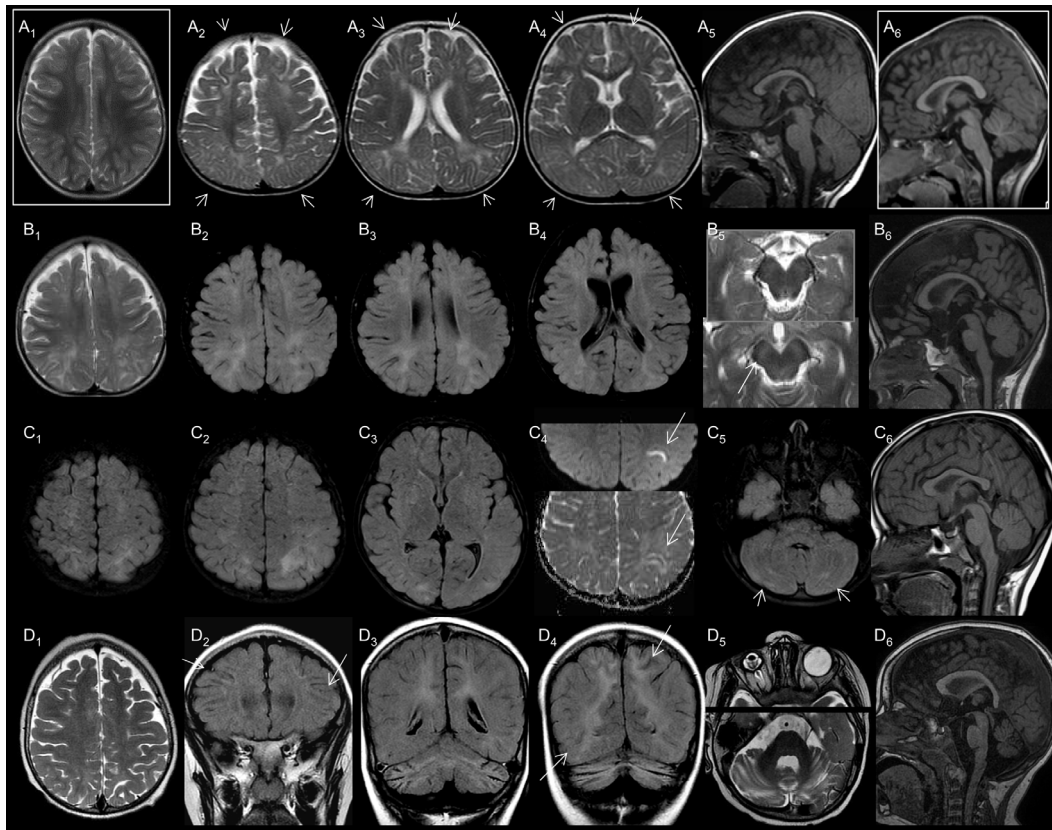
Wedge-like watershed injury. A, 15-month-old DHPRD_01 with frontal and parieto-occipital T2-hyperintensity (A₂₋₄, exemplary arrowheads, compare with A₁ from 15-month-old patient with normal imaging). Corpus callosum is too thin for age, in particular in its dorsal portion (A₅, compare with normal image in A₆). B, 20-month-old DHPRD_02 with wedge-like T2/FLAIR-hyperintensities of parieto-occipital and frontal white matter in (B₁₋₄) and mild T2-hyperintensity of substantia nigra (arrow in B₅ below; compare with normal image above from a 20-month-old patient examined at the same scanner using the same sequence). Global atrophy with widened ventricles (B₄) and a dorsally thin corpus callosum (B₆). C, In 6-year-old DHPRD_05 supratentorial changes are focally accentuated in the left parietal lobe (C₂) with restricted diffusion (arrows in C₄: DWI (above), ADC-map (below)). Cerebellar watershed injury (arrows in C₅). Absence of atrophy including normal corpus callosum (C₆). D, 4-year-old patient MAOAD_02 with watershed injury the depth of frontal sulci (D₂) and of parieto-occipital white matter and cortex (D₄), extensive cerebellar watershed injury (D₄), predominantly infratentorial atrophy (D₅) and a dorsally thin corpus callosum (D₆). NB persisting hyperplastic primary vitreus in right orbit (D₅). (T2w: A₁₋₄, B_{1,5}, D_{1,5}; FLAIR: B₂₋₄, C_{1-3,5}, D₂₋₄; DWI/ADC: C₄ above/below; T1w: A₅, A-D₆; normal images for comparison: A_{1,6}, B₅above)
